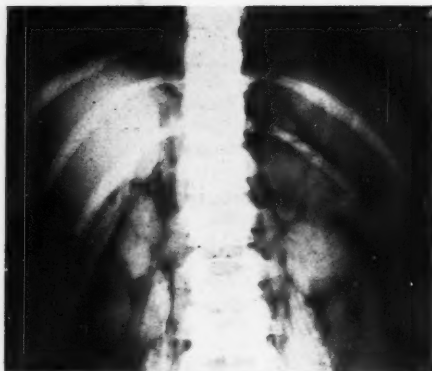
A film with air insufflation around both adrenals in a boy of six with adult masculinity. The right adrenal looks small. The left looks larger than normal but is of normal shape. From the roentgenogram a diagnosis of tumor could not be made.
